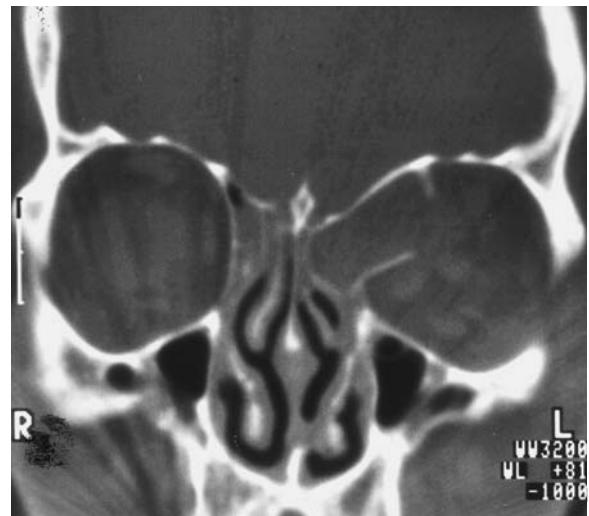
A 55-year-old man with subfebrile state and a prominent left orbital protrusion. Diagnosis: orbital complication due to pyocele of the ethmoid cells. Contrast-enhanced CT: a Axial view with intraorbital extension of the ethmoidal cell enlargement. Note marginal contrast enhancement and an intraorbital, postseptal formation, indicating intraorbital involvement of the inflammatory process. b Coronal bone window with a defect in the lateral wall of the enlarged, infected ethmoidal mucocele
